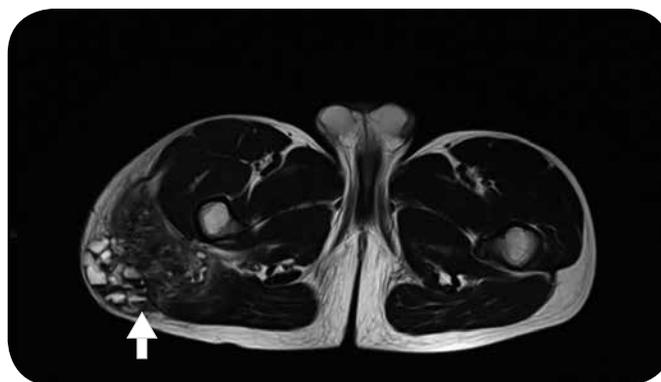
Axial plane, T2-weighted sequence: High signal mass, heterogeneous, with cystic component showing liquid-calcium levels inside (arrow).
